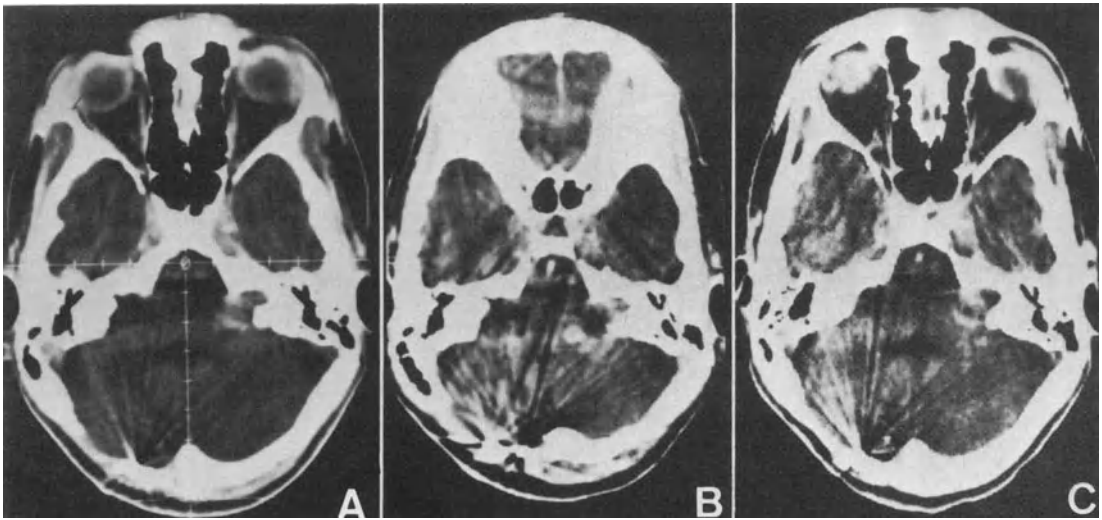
CT scan of a patient with bilateral acoustic neurinomas. The right-sided tumor was removed earlier via suboccipital surgery. The left-sided tumor was examined before (A), 5 (B), and 18 (C) months after stereotactic radiosurgery. Loss of contrast enhancement (B) and subsequent shrinkage (C) were seen.
